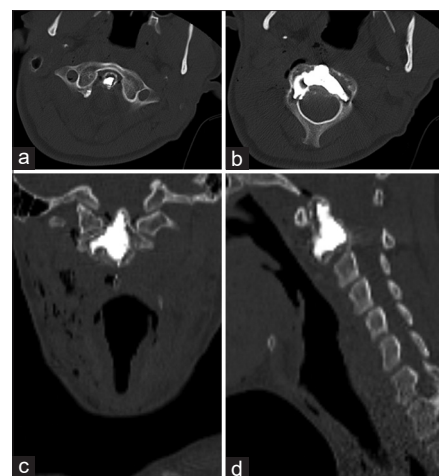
Early postoperation (C2 vertebroplasty) CT scan examination of the cervical spine. Axial, coronal, sagittal, and Scott views from left to right, respectively. CT: Computerized tomography. axial (a,b), coronal (c), sagittal (d)
